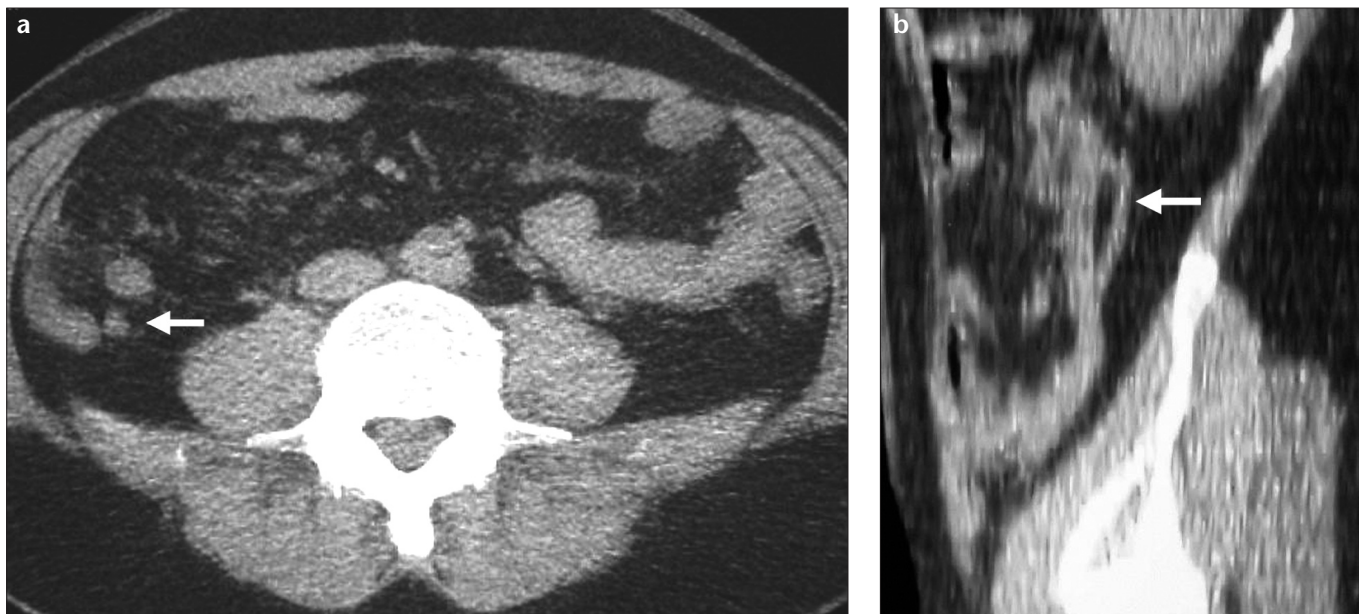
Axial CT section (a) and sagittal MIP image (b) show an appendix located in the retrocaecal position (arrow).
